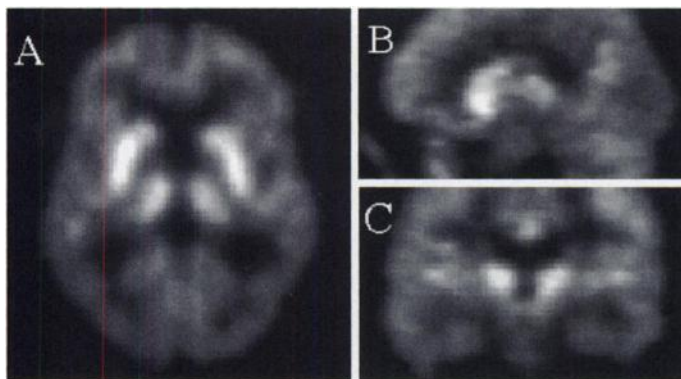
Uptake pattern of FDG seen within the brain of an HIV patient with no cognitive defect nor focal cerebral pathology. Transaxial (A), sagittal (B) and coronal (C) slices are shown. High uptake within the basal ganglia and thalami and increased separation of the thalami are seen; this was the common finding in the 16 patients with no cognitive dysfunction.
